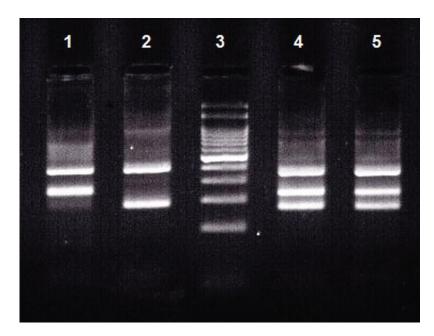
A representative 2% agarose gel electrophoresis of for identification of the HOTAIR rs920778 genotypes. Lanes 1: TT genotype; lane 2: CC genotype; lanes 4 and 5: CT genotype; and lane 3: DNA size marker (100 bp).
